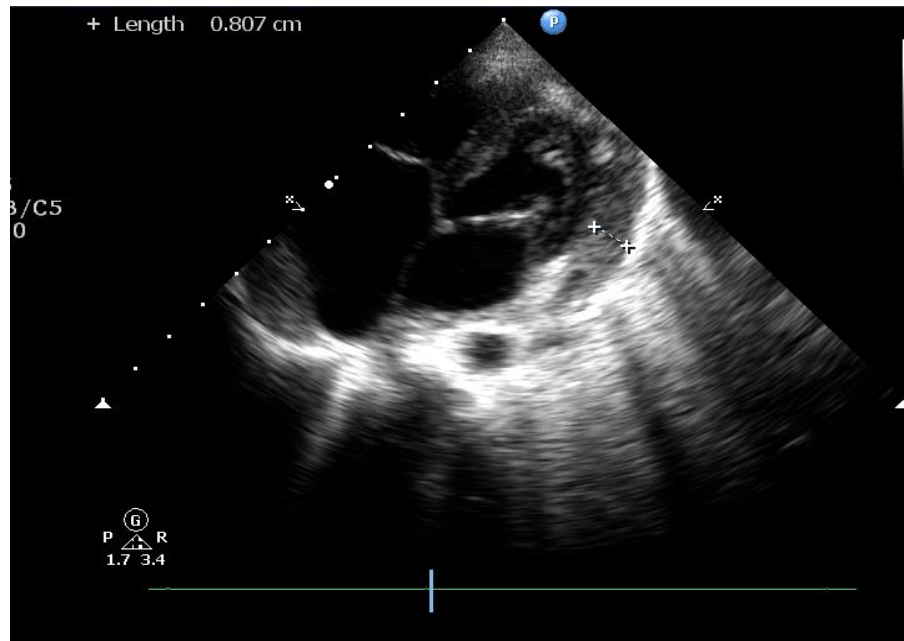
Echocardiography showing pericardial effusion and hepato-pericardial fistula.
